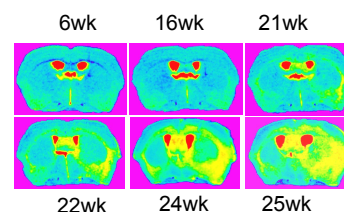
Tumor growth over time by MRI
